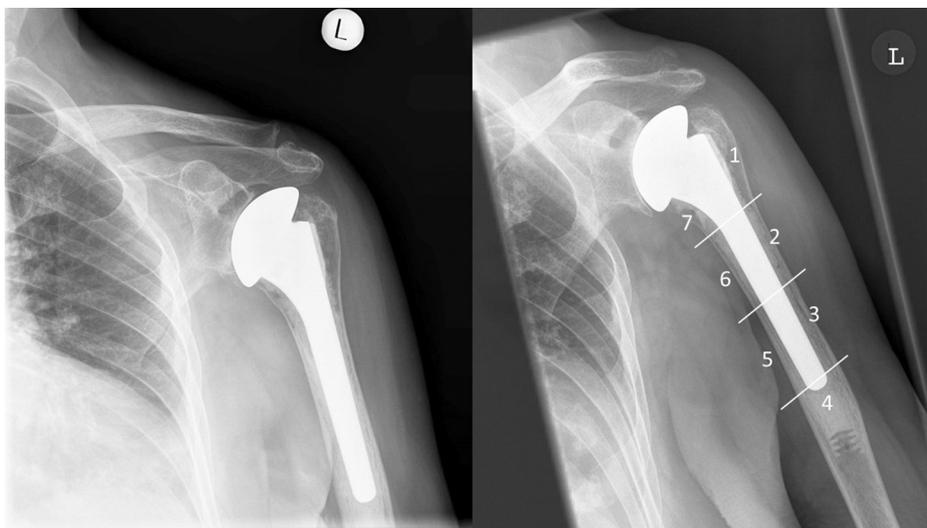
Anteroposterior x-ray of a left shoulder after cemented anatomical reconstruction of the proximal humerus in an 87-year-old female with primary osteoarthritis of the shoulder. The humerus was divided into seven zones as reported previously: zones 1 and 7 referred to the lateral and medial sides of the proximal third of the stem, zones 2 and 6 referred to the lateral and medial sides of the middle third, zones 3 and 5 referred to the lateral and medial sides of the distal third, and zone 4 was at the tip of the stem [26]. Left: 1 year postoperatively, right: 10 years postoperatively.
